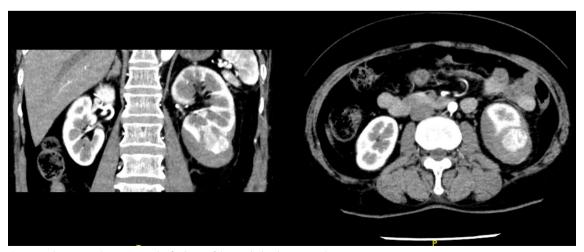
Computed tomography angiography findings of the epithelioid angiomyolipoma
